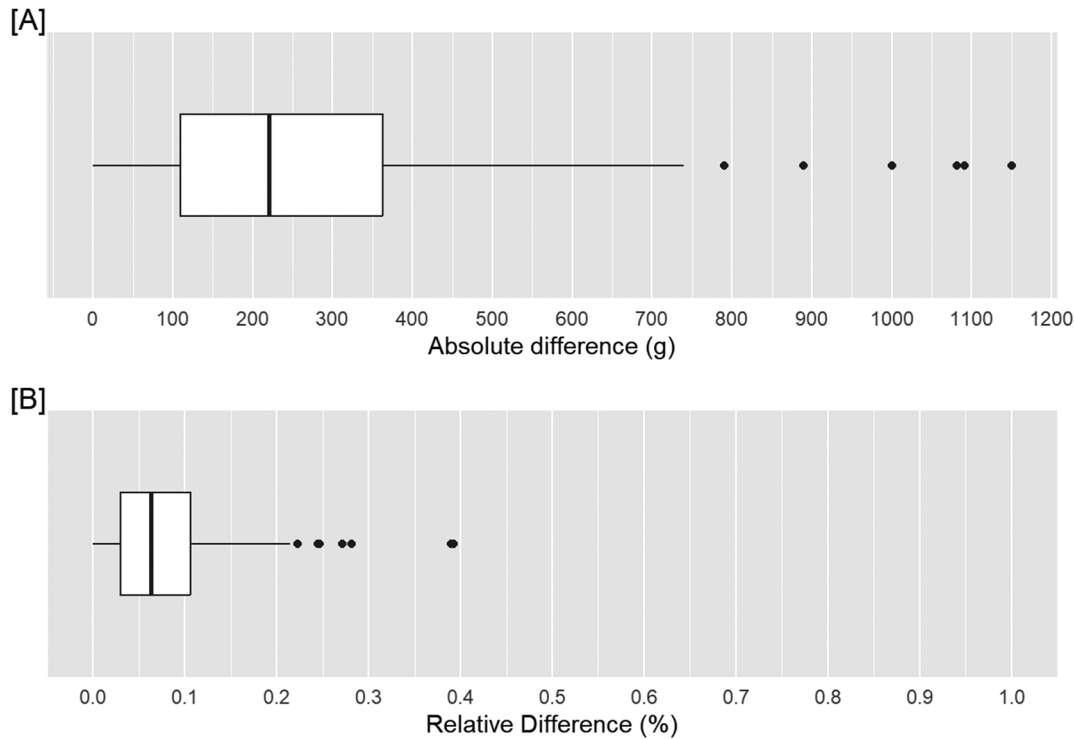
Boxplot of absolute (A) and relative (B) differences between measured neonatal weight and ultrasound estimated fetal weight in the week before delivery.
